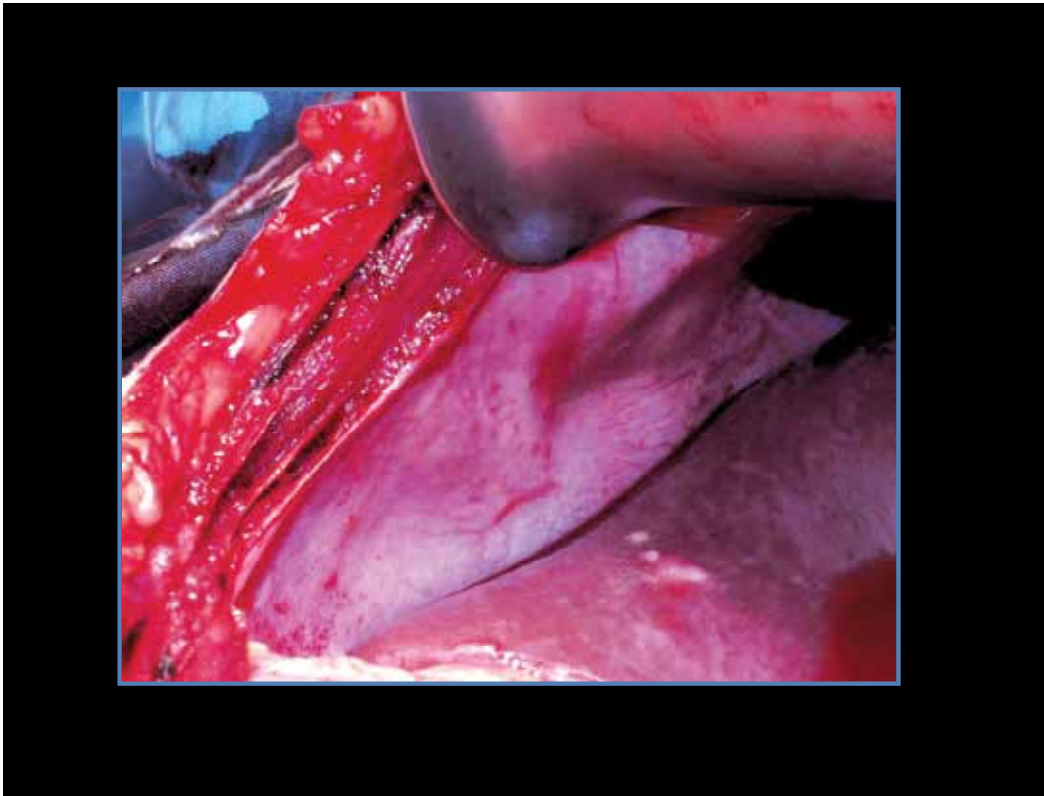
This patient with a colorectal cancer had a small subcapsular lesion shown on a CT. At laparoscopy the subcapsular lesion was biopsied, which was positive for a metastasis. The patient had a laparotomy 3 weeks latter. The picture shows multiple tiny serosal deposits
